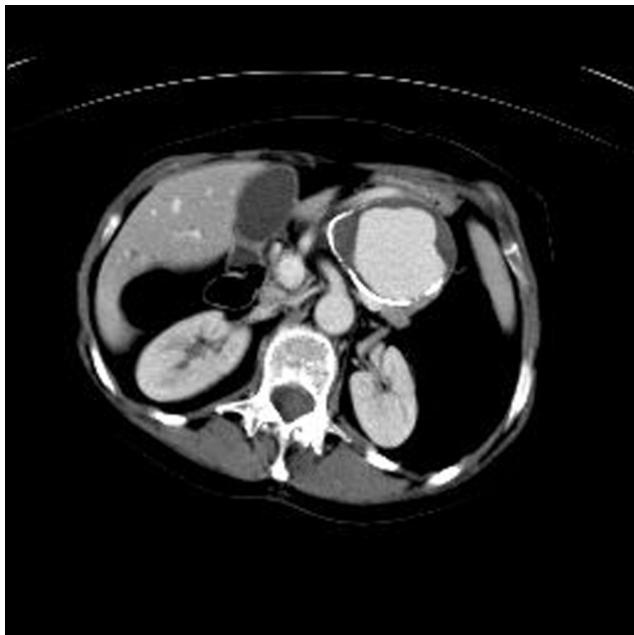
CT pneumocolon demonstrating 7 cm splenic artery aneurysm.
